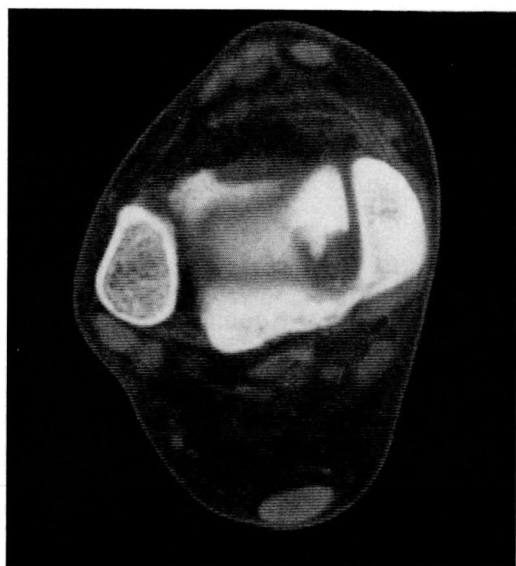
CT showed crater on the talus with osteochondral fragment.
